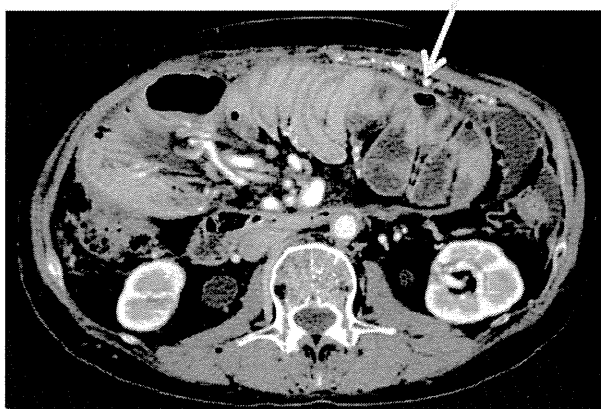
Computed tomography of the abdomen showing dilated loops of the small bowel with a small amount of ascites
